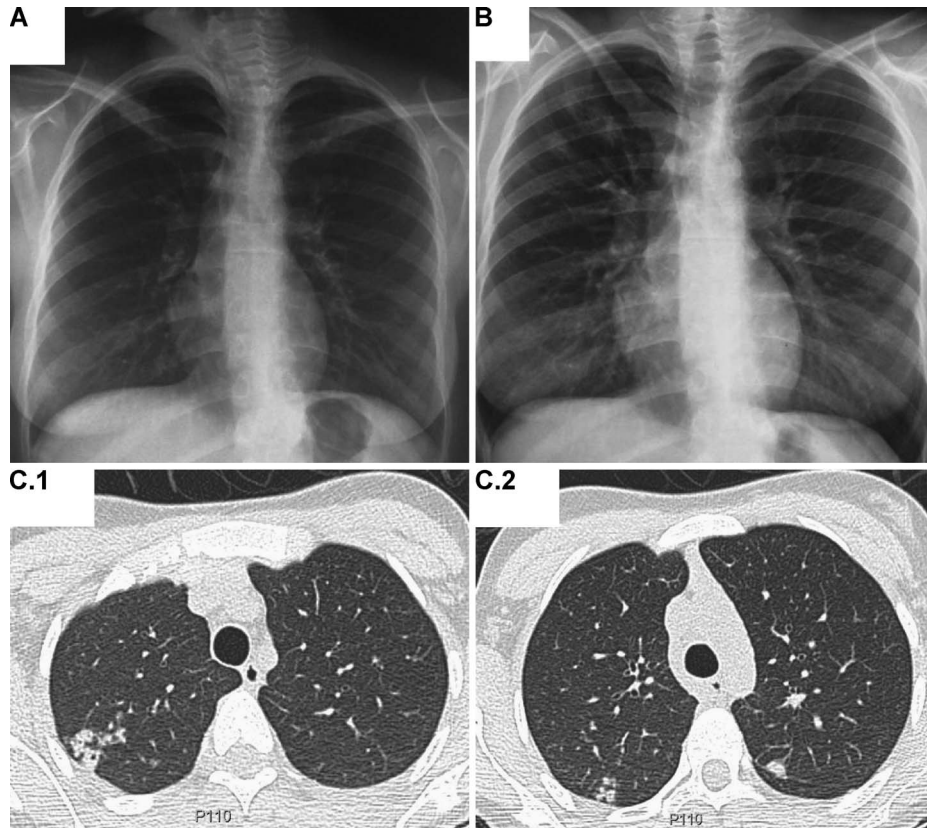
Figure A) Baseline (21 April 2015) CXR in nasopharyngeal Xpert-positive contact. B) CXR at 12 weeks (30 July 2015) showing new right upper lobe infiltrates. C 1 and 2) high-resolution chest computed tomography scan at 12 weeks confirming bilateral upper lobe nodular infiltrates with tree-in-bud areas. CXR = chest X-ray.
